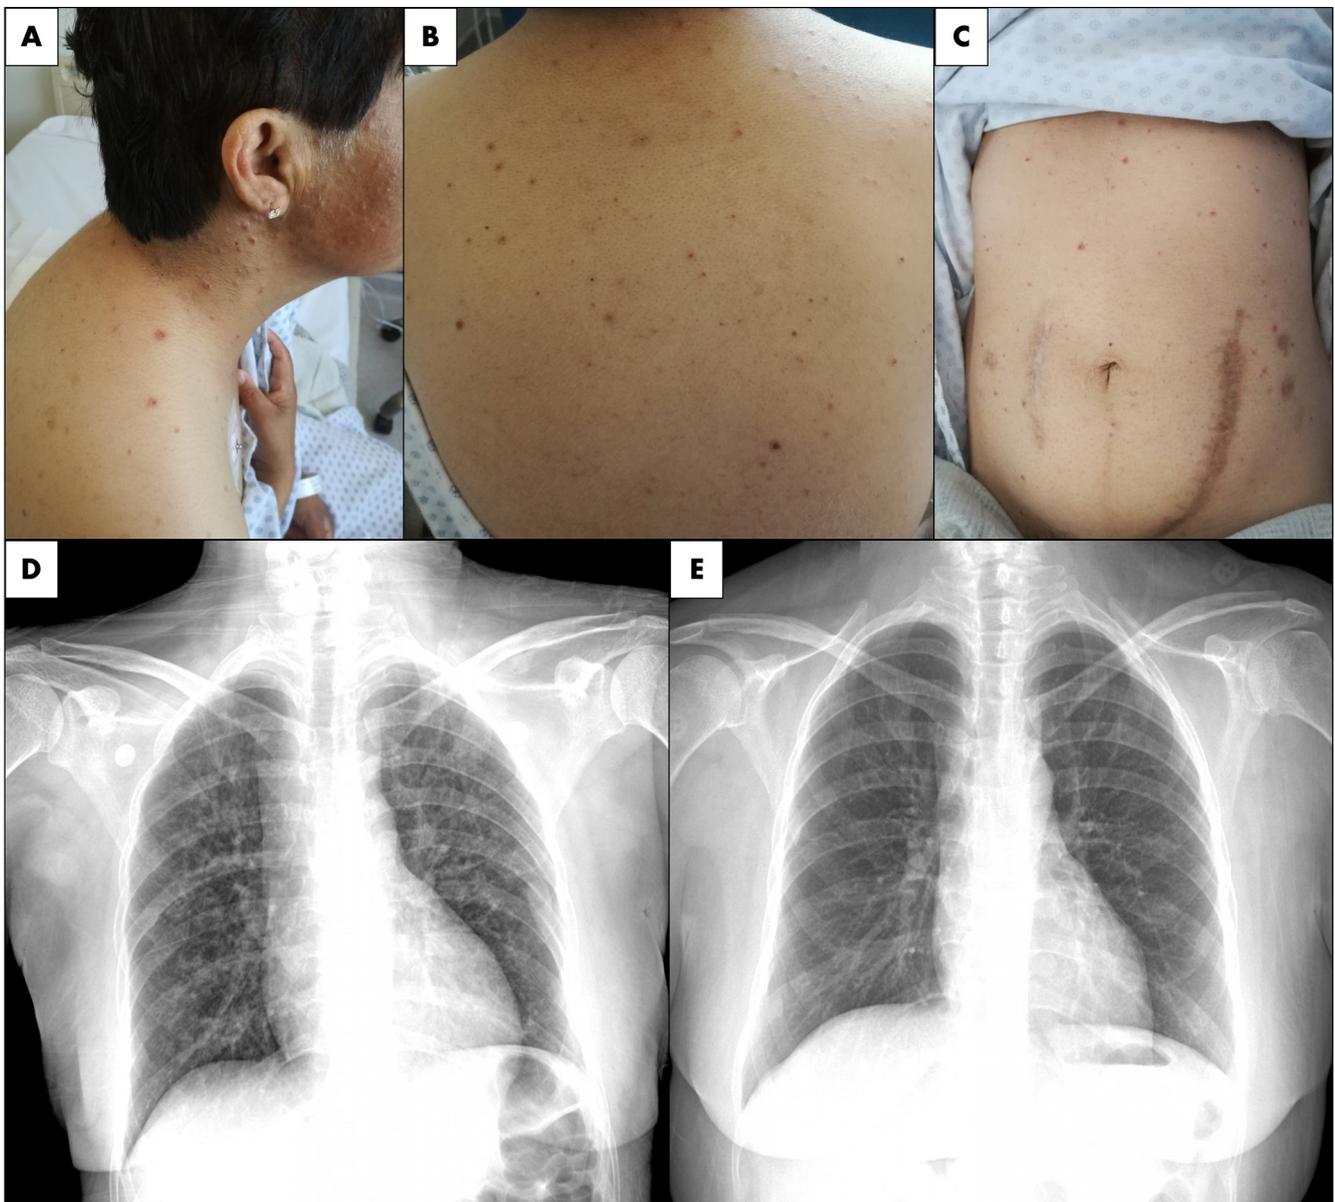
A vesicular rash in different stages of development distributed on the face (A), trunk, and abdomen (B, C) in a kidney allograft recipient secondary to vOka-strain infection after herpes-zoster vaccination. (D) A chest X-ray revealed bilateral interstitial infiltrates; a chest X-ray taken one year before is depicted for comparison (E).
